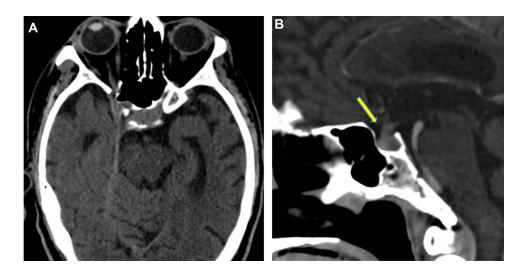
(A, B). Enhanced cranial CT scan axial (A) and sagittal plane (B) revealed an enlarged pituitary gland and a significantly thickened pituitary stalk (yellow arrow) with moderate enhancement. No evident erosion of the clivus.
